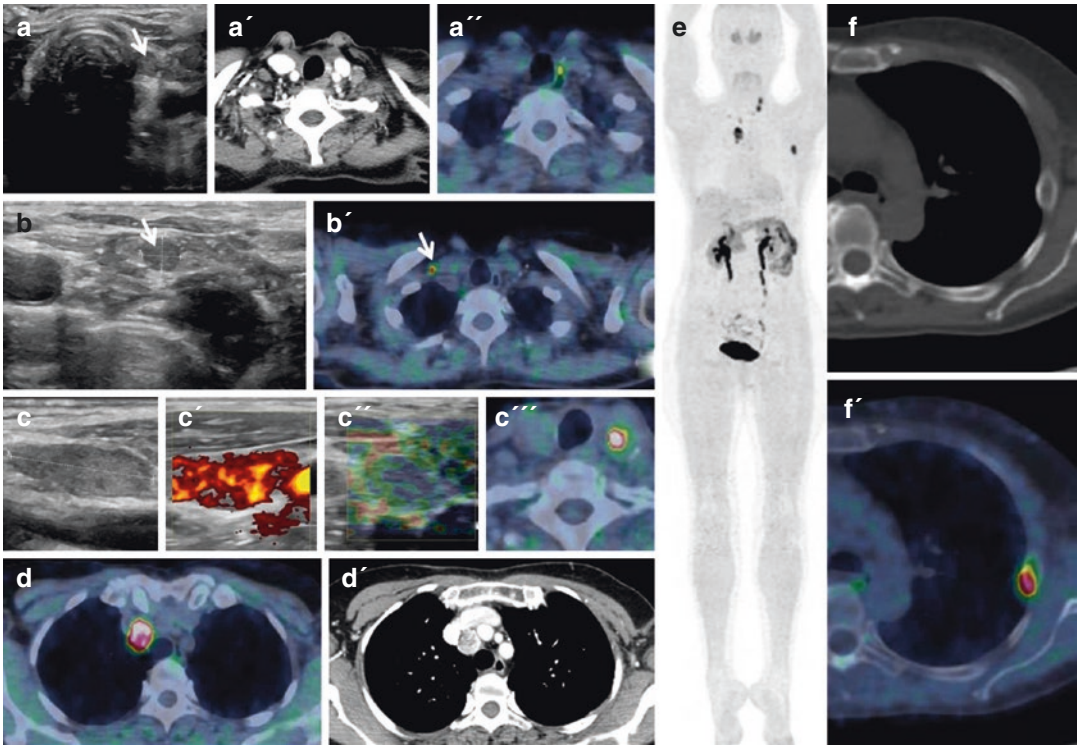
A 49-year-old male patient examined by ultrasonography, contrast enhanced CT, and ^{18}F -DOPA PET/CT, due to rise of calcitonin, 2 years after radical thyroidectomy for medullary thyroid cancer. Axial ultrasound (a), contrast enhanced CT (a'), and PET/CT (a'') show a 1-cm-wide para-tracheal lymph node with pathologic tracer uptake. Axial ultrasound (b) and PET/CT (b') display a further right retro-clavicular lymph node (arrows). Axial ultrasound (c) shows tumor relapse in the left thyroid bed with intense blood flow in Doppler (c'), ample areas of hard strain, prevalently arranged in a constant manner at the periphery or at the center of the nodule, as assessed by
